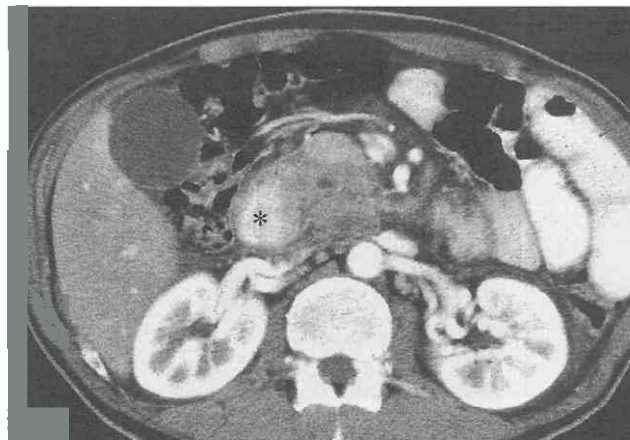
Pancreatitis with secondary duodenal involvement. CT scan shows concentric duodenal wall thickening with heterogeneous contrast enhancement of the enlarged head of the pancreas.
